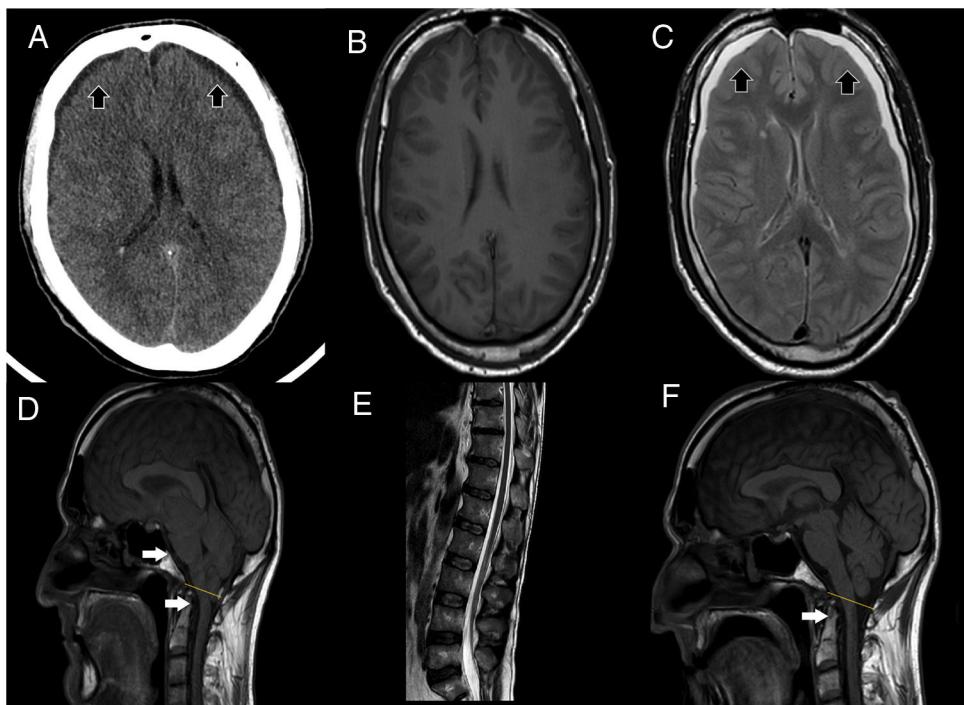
(A) Cranial CT scan shows bilateral subdural collections (as the black arrows point), without associated mass-effect, suggestive of subdural hygromas. (B, C) It stands out collapsed lateral ventricles, also bilateral subdural collections, hypointense in T1 (B), hyperintense in T2 (C) sequences (as the black arrows point), without enhancement after contrast administration, supporting the suspicion of subdural hygromas. (D) T1 weight sagittal sequence showed severe downward displacement of cerebellar tonsils (as the white arrows point) below the McRae line (represented by the yellow line), distortion of the brainstem structures and descent of the splenium of the corpus callosum. (E) Spinal MRI showing inferior and ventral displacement of the medullary cord. (F) Resolution of downward displacement of brainstem (as the white arrows point) and cerebellar structures (cerebellar tonsils are placed above the McRae line, represented by the yellow line). Resolution of the rest of the signs suggestive of brain sagging.
